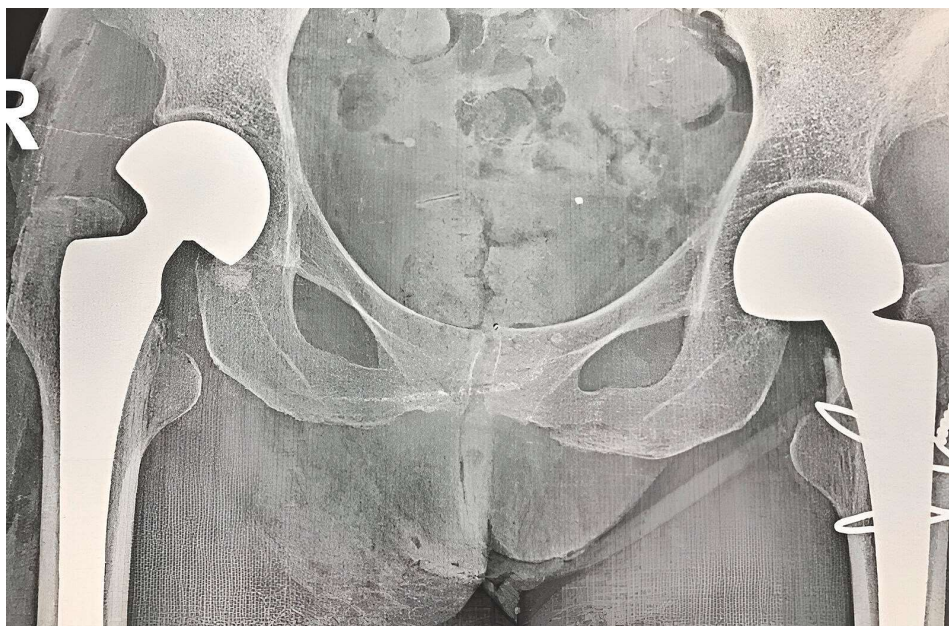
Radiograph after the operation, bilateral cementless bipolar hemiarthroplasty.
